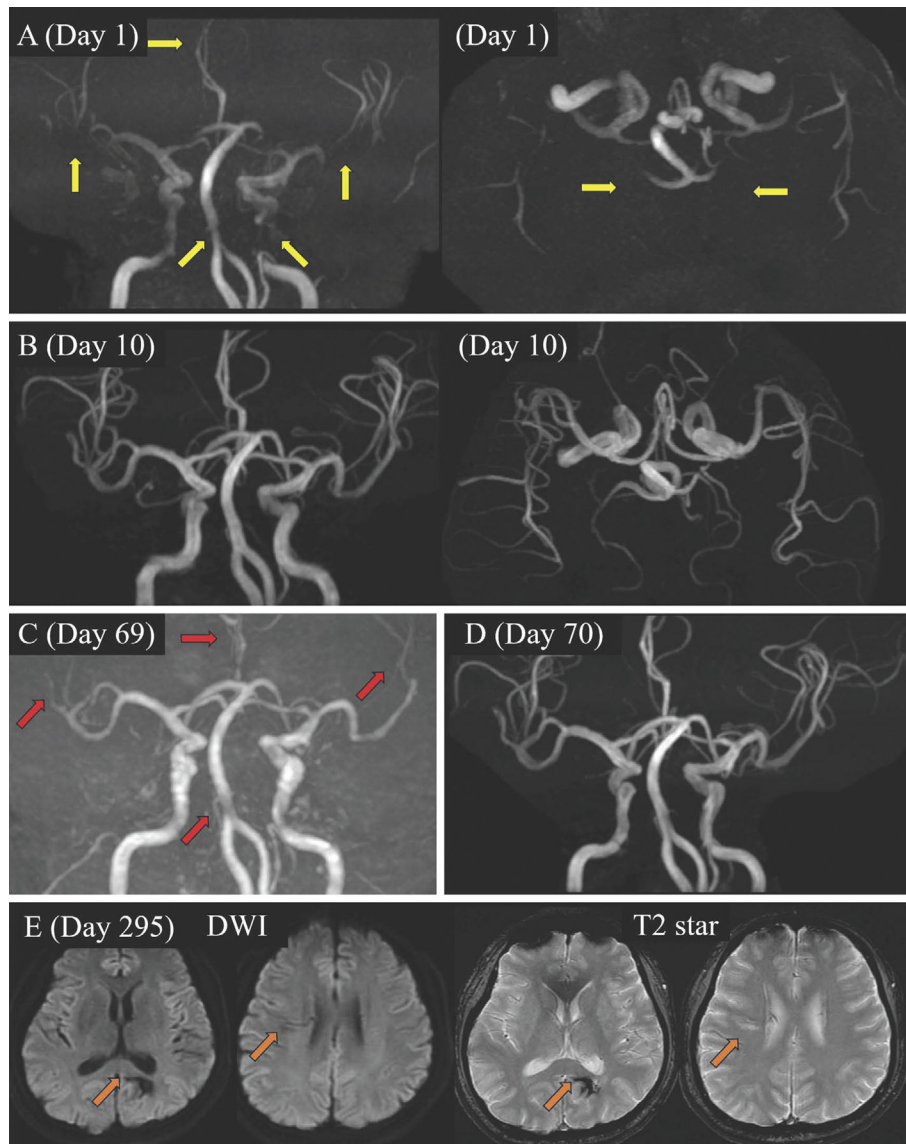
Time course of the MRA and MRI findings 1 (A), 10 (B), 69 (C), 70 (D), and 295 days (E) after onset. (A) Multifocal segmental cerebral artery vasoconstriction is most prominent in the bilateral posterior cerebral arteries (yellow arrows). (B) Disappearance of the abnormal findings observed on day 1. (C) Multiple cerebral artery stenosis (red arrows). (D) Normalization of cerebral artery stenosis. (E) No new lesions were detected (orange arrows).
